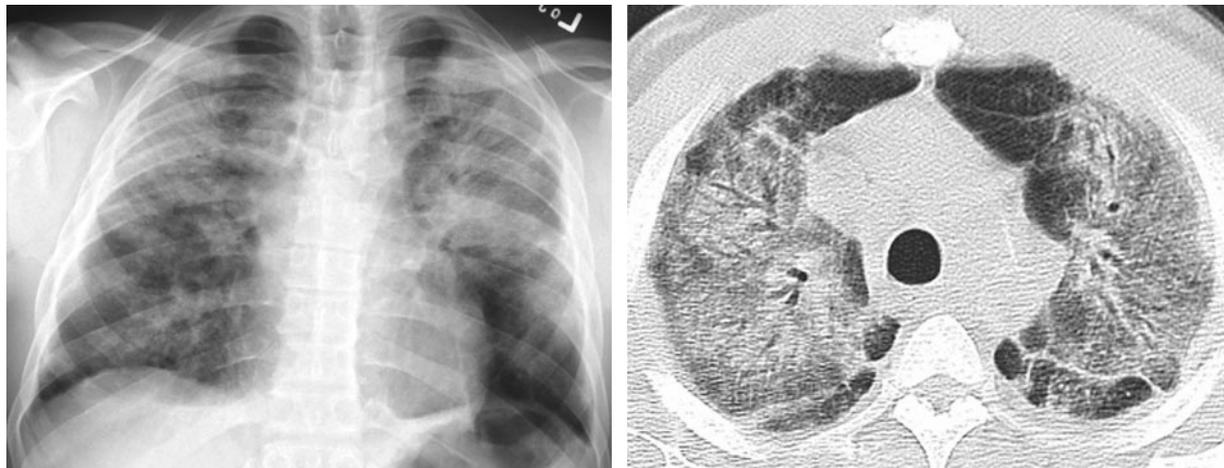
Pulmonary eosinophilia in a patient with a history of cocaine abuse. (a) Chest radiograph demonstrates bilateral parenchymal opacities with a predominantly peripheral distribution. (b) CT scan exhibits extensive bilateral disease with ground-glass opacities and airspace consolidation.
